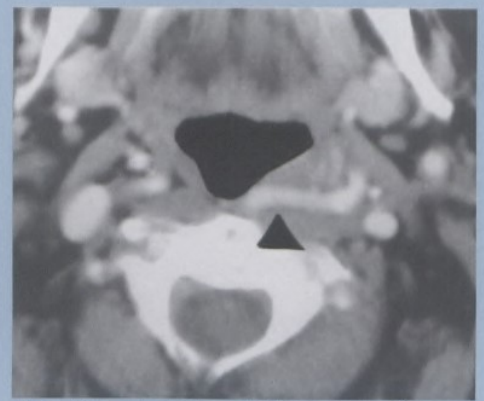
Axial contrast enhanced CT scan showing the medial loop of the left internal carotid artery (arrowhead).
